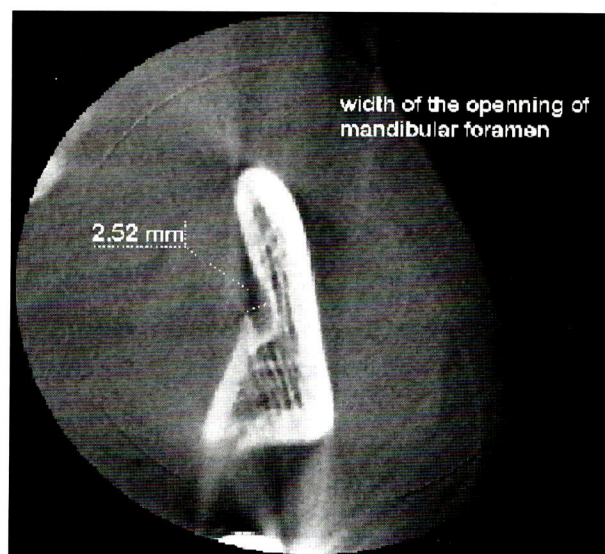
The center and the mandibular foramen opening width in CBCT
